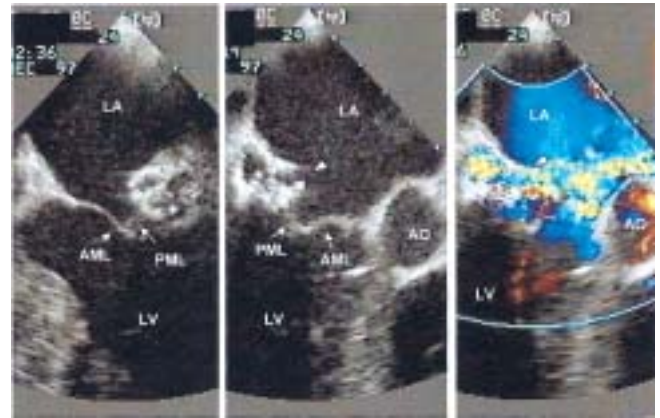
Same patient as Figure 1. Transesophageal examination conducted three weeks later. The vegetation has disappeared; instead, a partitioned abscess cavity is present within the annulus (asterisk), and color-flow Doppler study shows fistulization of the ring abscess into the left atrium (arrowhead). Left panel: Horizontal plane; middle and right panel: 115° oblique plane. AML: Anterior mitral leaflet; AO: Aorta; LA: Left atrium; LV: Left ventricle; PML: Posterior mitral leaflet.
